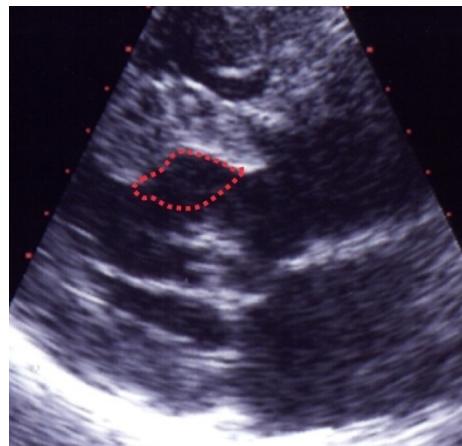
Echocardiographic visualization of the septal trough produced by a myectomy procedure
